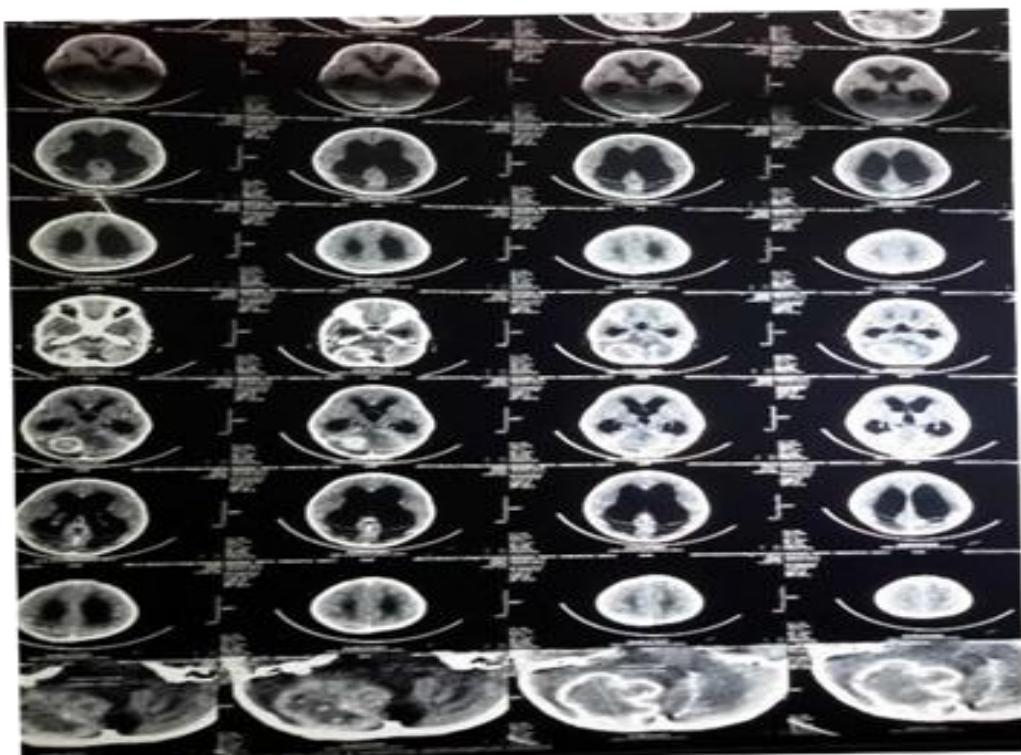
CT scan showing tuberculoma & hydrocephalus
